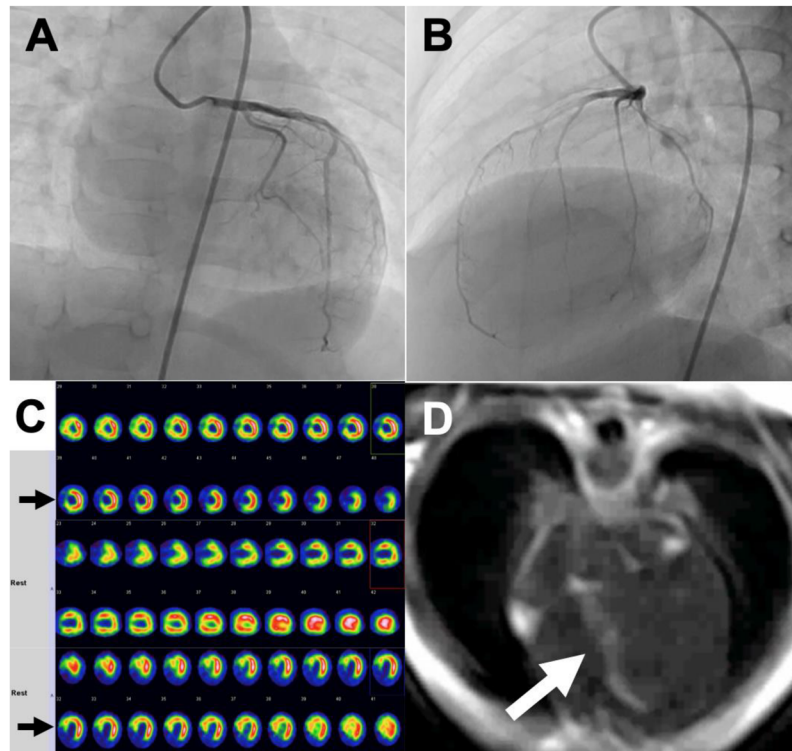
Postoperative selective left coronary arterial angiography (A: frontal view, and B: lateral view). (C) Myocardial perfusion scintigraphy shows a perfusion defect (black arrow). (D) Cardiac magnetic resonance shows that the interventricular septum has late gadolinium enhancement (white arrow).
